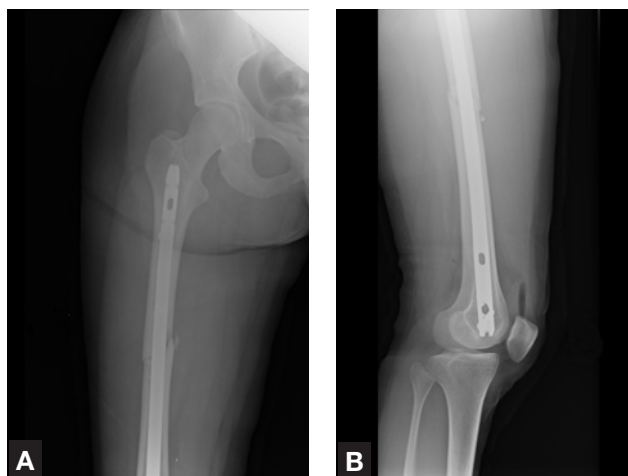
Anteroposterior (A) and lateral (B) postoperative x-rays.
